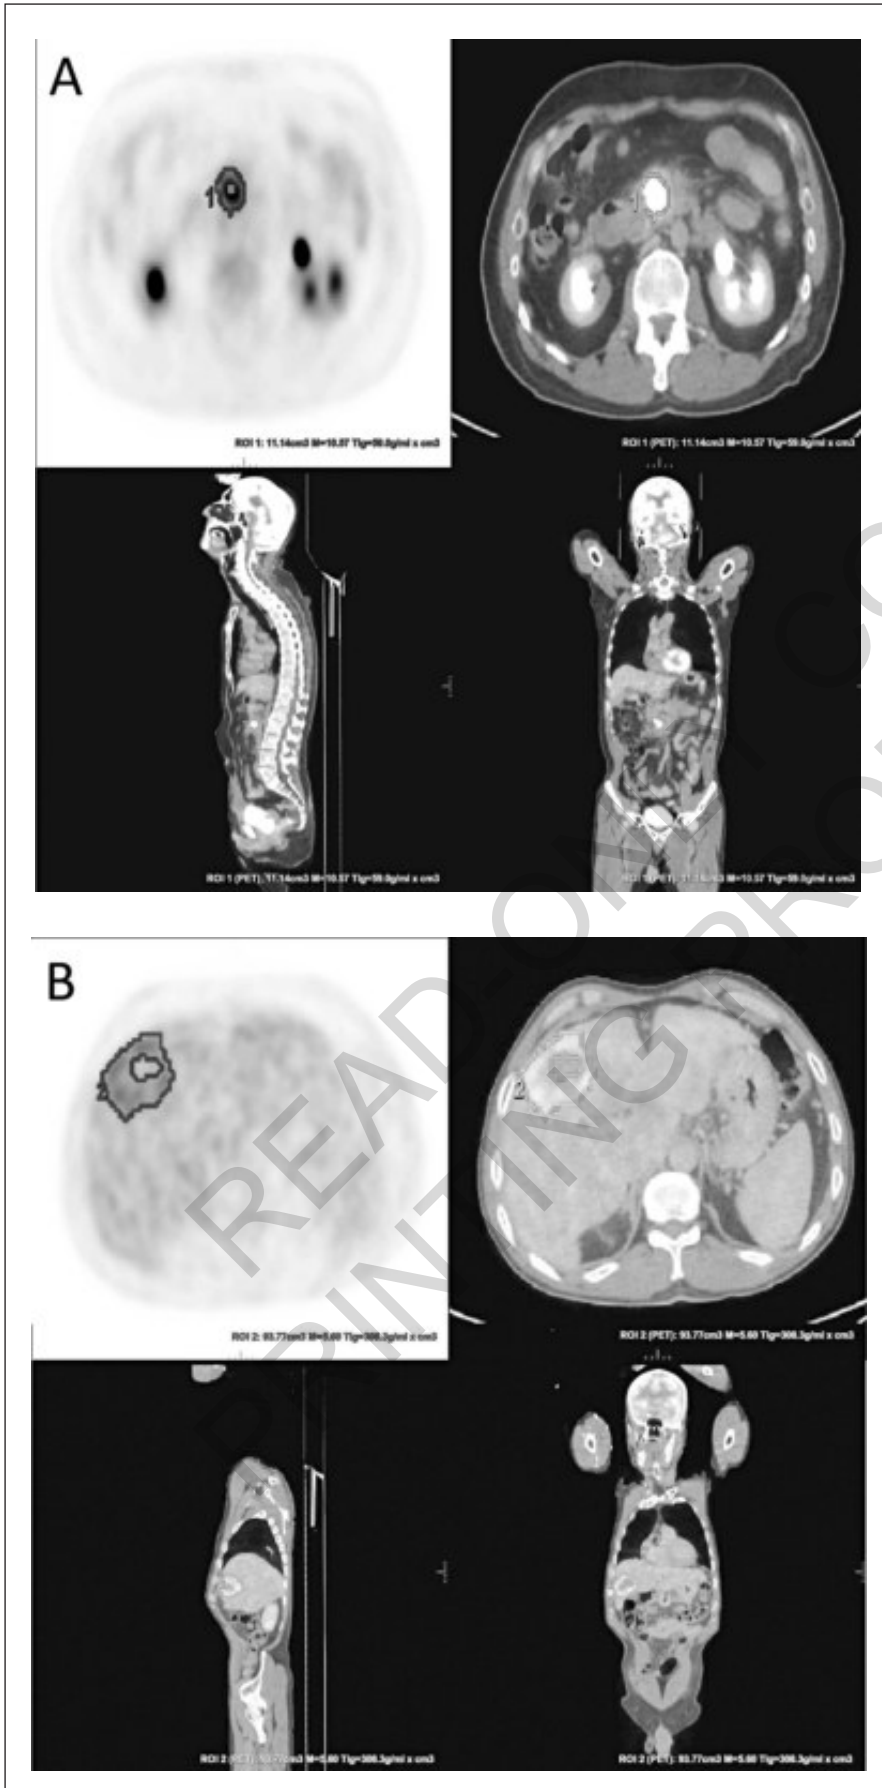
A) A 71-year-old female patient with pancreas adenocarcinoma; primary tumor MTV: 21,62 cm<sup>3</sup>, primary tumor TLG: 63,6 g/ml.cm<sup>3</sup>, primary tumor SUVmax: 4,64; B) liver metastasis MTV: 93,77 cm<sup>3</sup>, liver metastasis TLG: 308,3 g/ml.cm<sup>3</sup>, liver metastasis SUVmax: 5,6.
